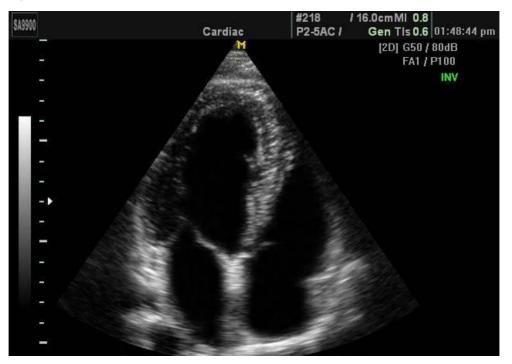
Apical 4 chamber view (<u>parvliuk and</u> <u>povalishko, 2013</u>).
